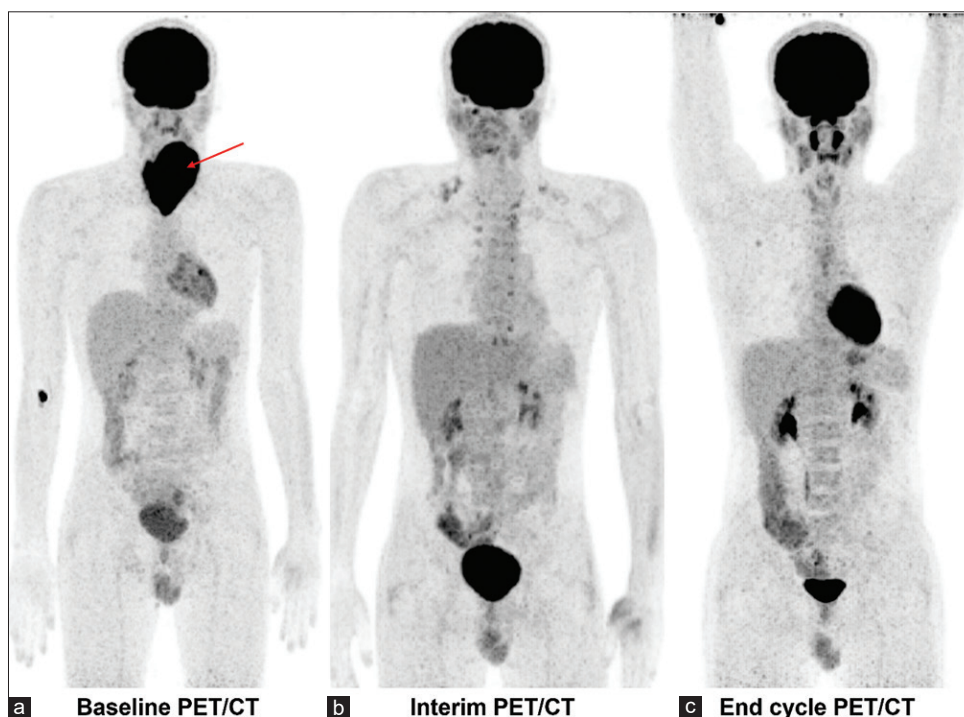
Baseline FDG PET/CT maximum intensity projection (MIP) image (a) revealed increased tracer uptake in the mass lesion in the neck (red arrow), Interim FDG PET/CT MIP image (b) revealed no significant diseases suggestive of Excellent response. End cycle FDG PET/CT MIP image (c) revealed no significant pathological uptake in the body suggestive of Complete response
